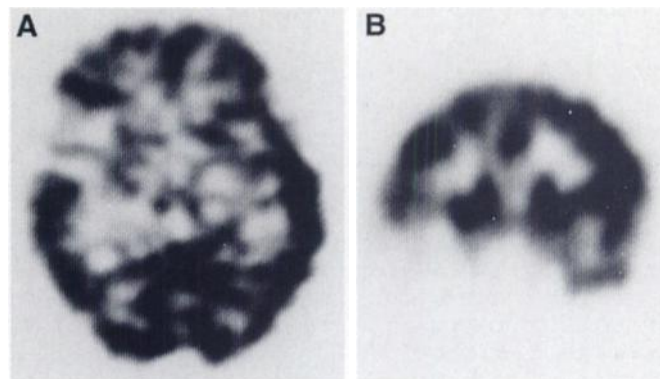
SPECT images of Patient 2. Note decreased uptake of ^{99m}Tc-ECD in right temporal lobe. Compare with uptake of ^{99m}Tc-HMPAO in Figure 1.
